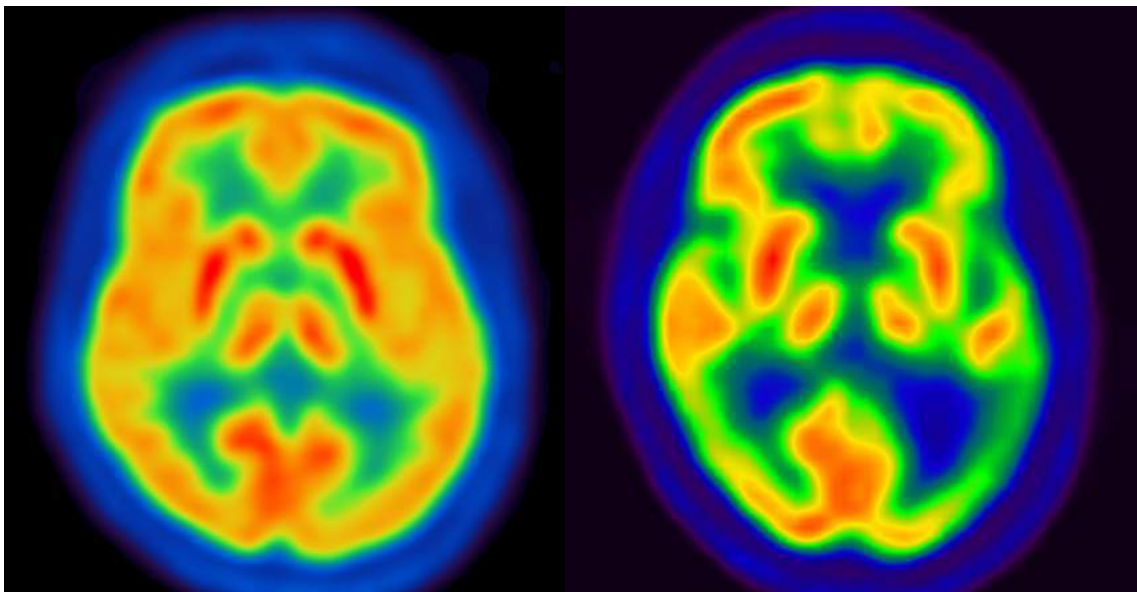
A) Normal ^{18}F FDG-PET metabolism in healthy control. B) Characteristic ^{18}F FDG-PET hypometabolism in AD pathology.
